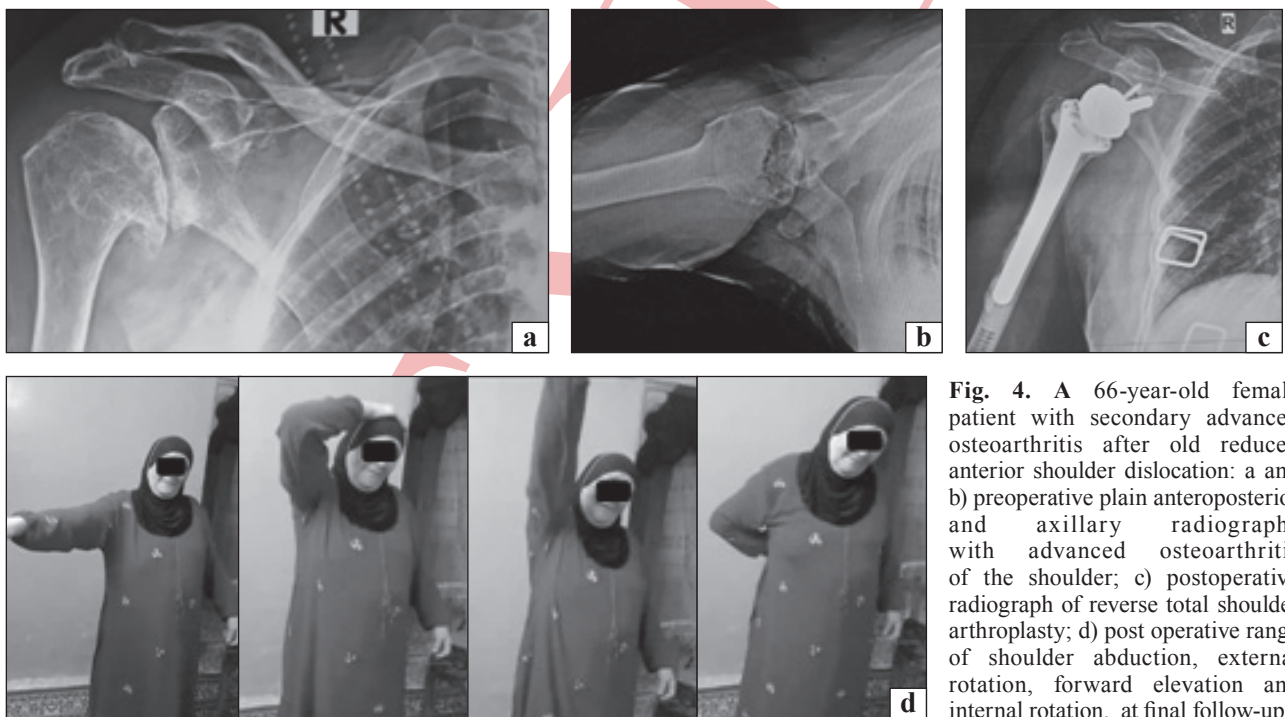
A 66-year-old female patient with secondary advanced osteoarthritis after old reduced anterior shoulder dislocation: a and b) preoperative plain anteroposterior and axillary radiographs with advanced osteoarthritis of the shoulder; c) postoperative radiograph of reverse total shoulder arthroplasty; d) post operative range of shoulder abduction, external rotation, forward elevation and internal rotation, at final follow-up
